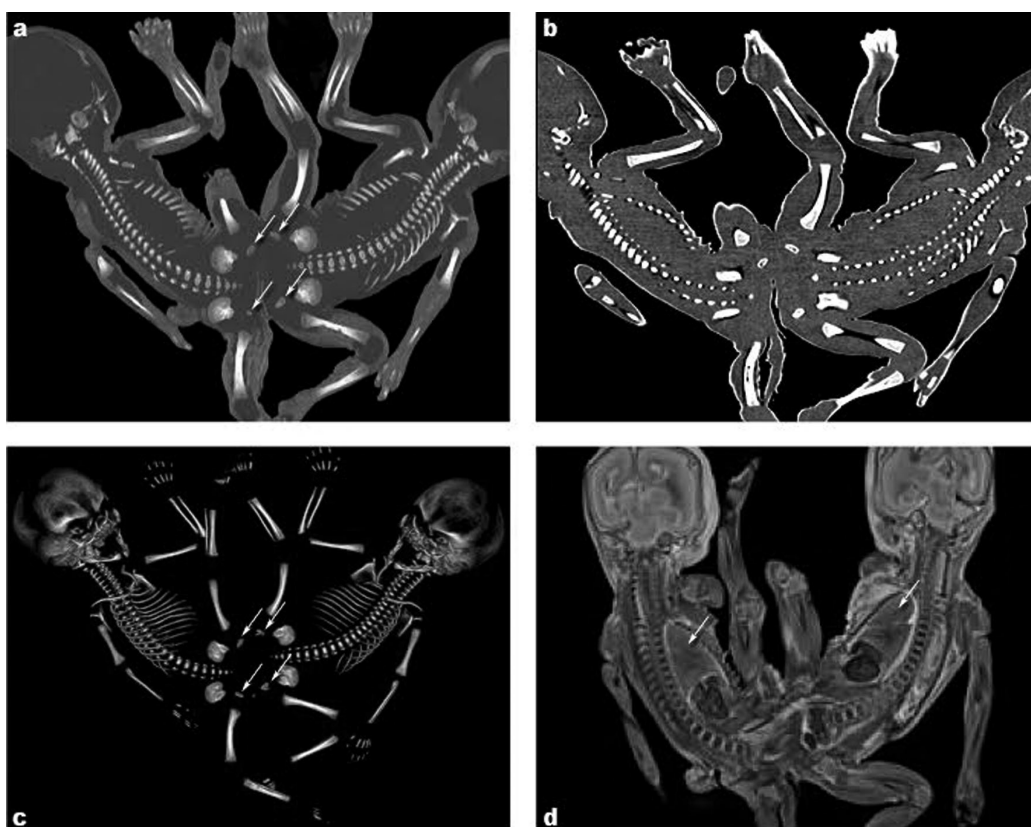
Radiological findings. (a) CT scan with bone window setting demonstrating the presence of all the ossification nuclei of pelvis and femur heads in both twins (white arrows). (b) CT multi planar reconstruction showing the absence of any junction site at bone level. (c) Shaded surface-display (SSD) reconstruction of the fetal skeleton confirmed the presence of all the pelvic ossification nuclei of each fetus (white arrows). (d) T2 MRI image visualizing fetal visceral organs, as fetal lungs (white arrows).
